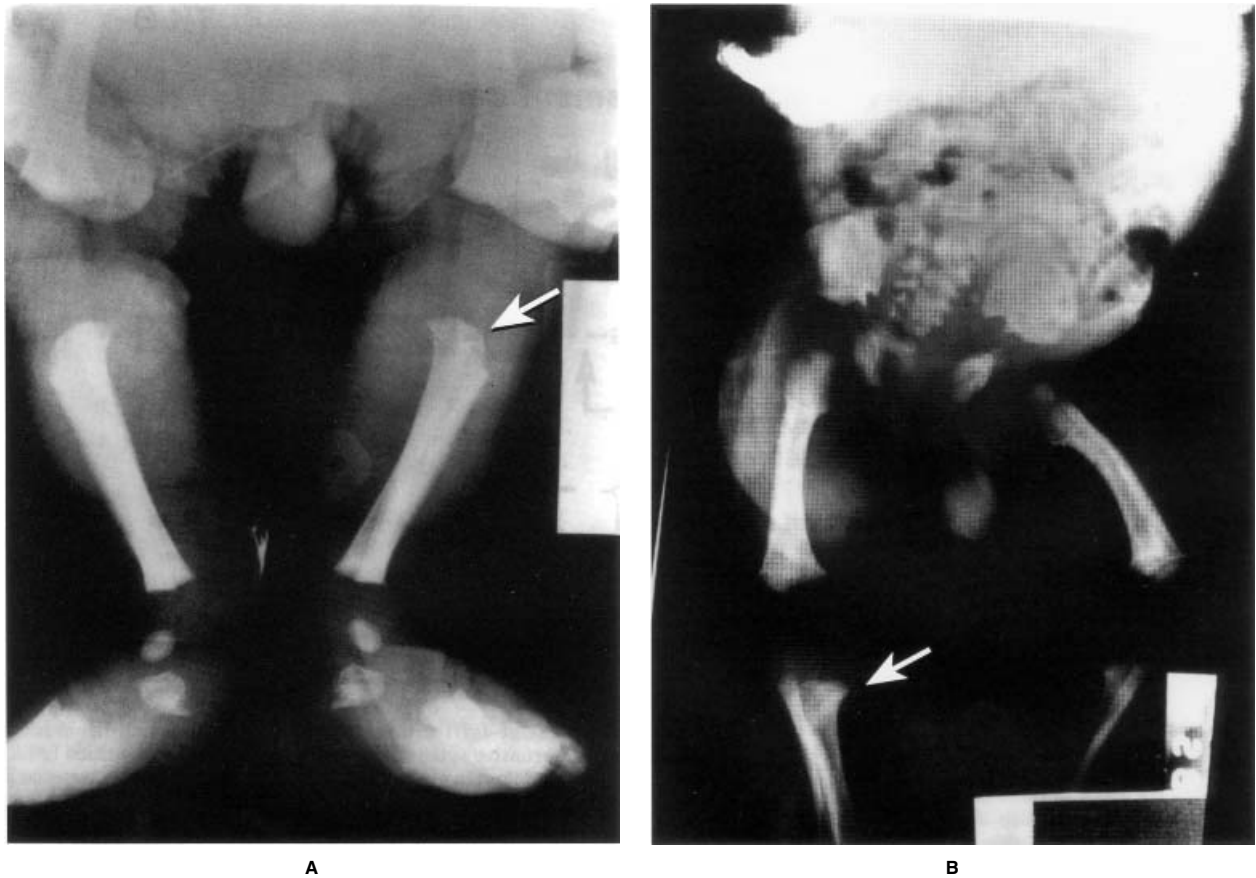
Radiographic features of achondroplasia. Lower limbs in a young child. Note widened metaphyses, “chevron seat” epiphyses (arrowed), and short long bones. Radiographically, manifestations can also include lumbar lordosis and mild thoracolumbar kyphosis, with anterior beaking of the first and/or second lumbar vertebrae; small cuboid-shaped vertebral bodies with short pedicles and progressive narrowing of the lumbar interpedicular distance; small iliac wings with narrow greater sciatic notch; short tubular bones; metaphyseal flaring; short trident hand with short proximal midphalanges; and short femoral neck. (Figures courtesy of Dr. Ralph Lachman, Cedars-Sinai Medical Center, Los Angeles.)
